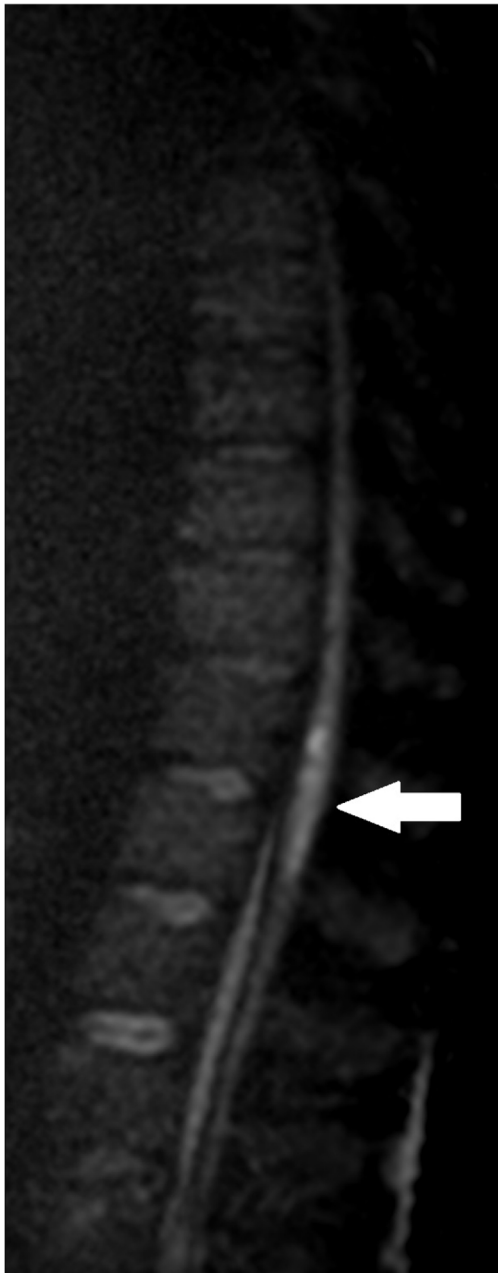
MRI. Sagittal plane of diffusion-weighted image showing diffusion restriction in the distal portion of the cord and conus medullaris (white arrow), possibly related to acute ischaemic injury.
